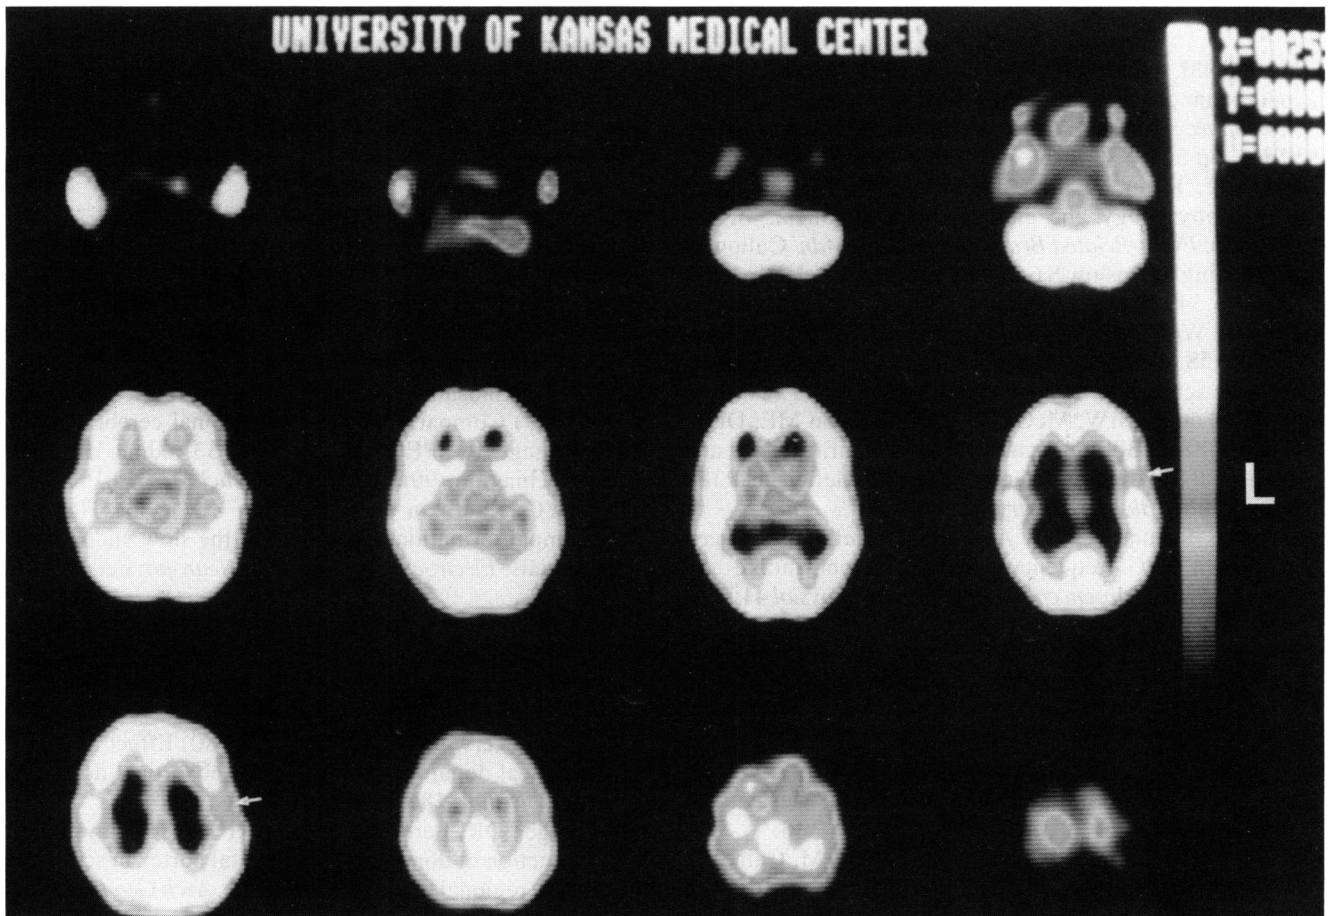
SPECT transaxial brain images reveal a significant decrease in left frontotemporal HMPAO activity (arrows). A smaller decrease in the right frontotemporal region is also evident.
